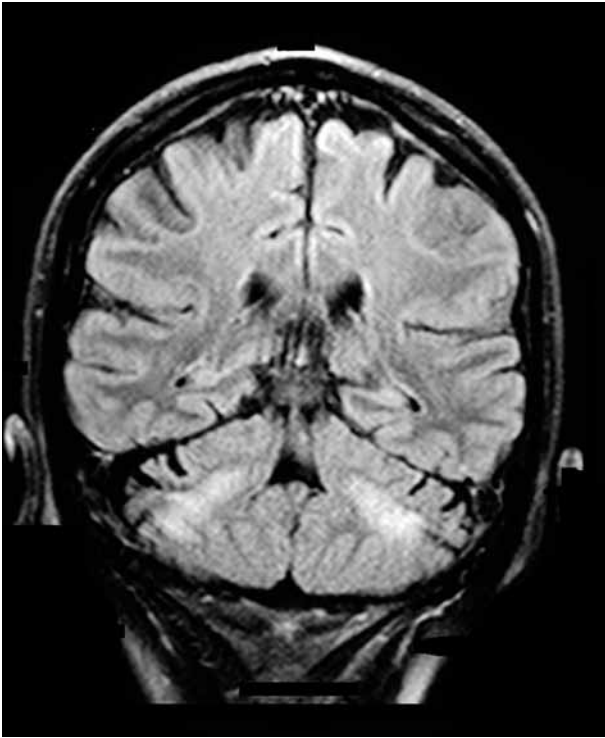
Brain MRI of patient, homozygous for recessive *POLG* A467T mutation. Note symmetric cerebellar white matter lesions on T2-weighted image.
